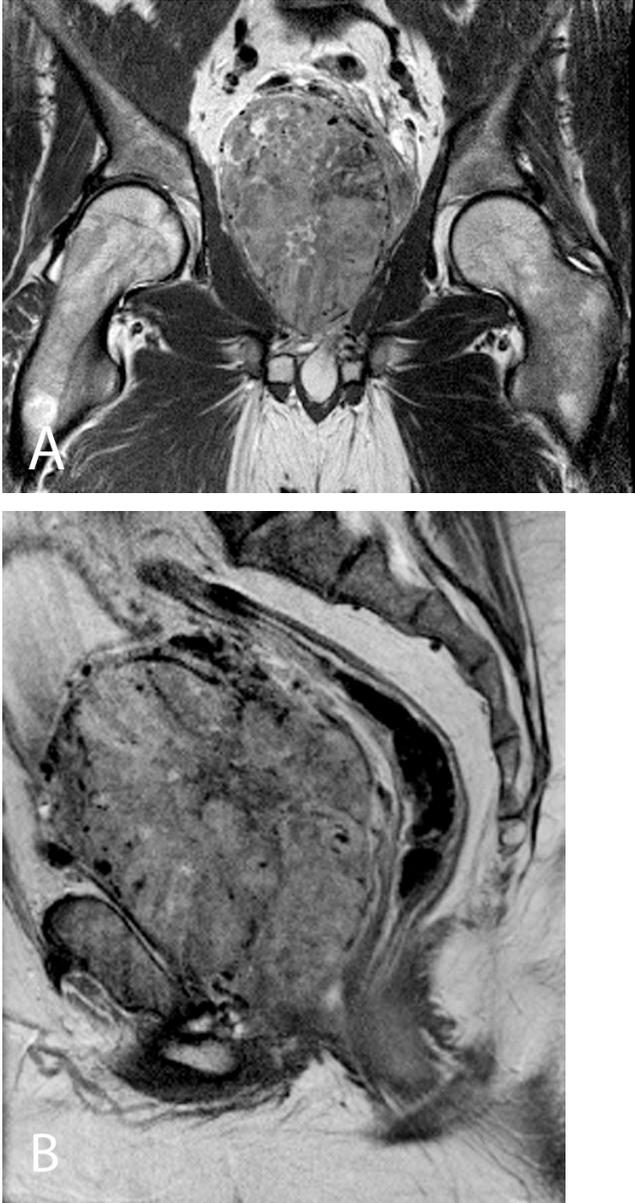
37-year-old male with solitary fibrous tumor of the prostate. Coronal (A) and sagittal (B) T2-weighted images reveal large, mildly heterogeneous mass with nonspecific hypointense foci, which displaces rectum posteriorly.
